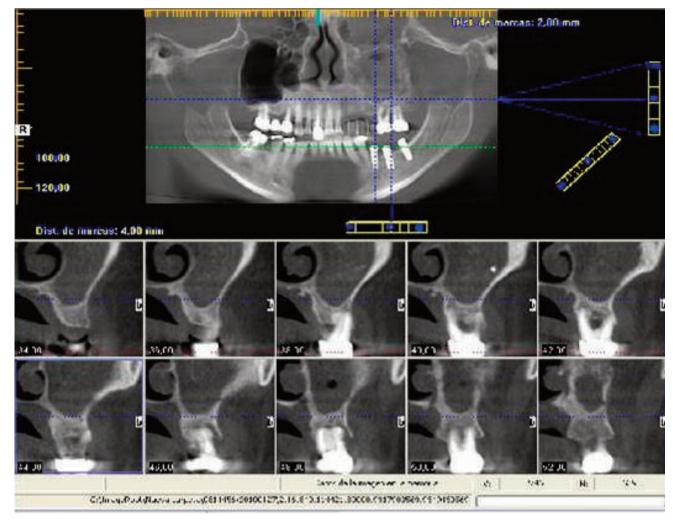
Panoramic view of a CBCT by means of iCATVision with almost complete occupancy of the left maxillary sinus.
